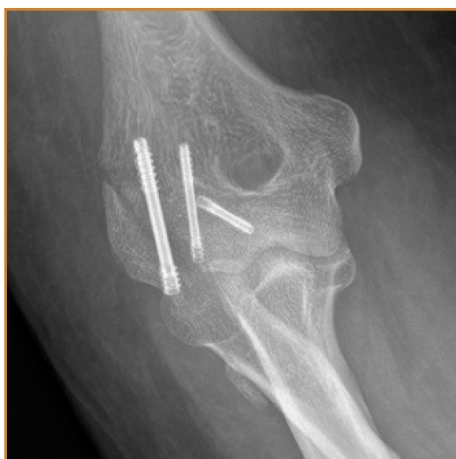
Anterior posterior radiograph demonstrating anatomic reduction to the distal intra-articular humerus fracture with anatomic reduction and bony consolidation.
